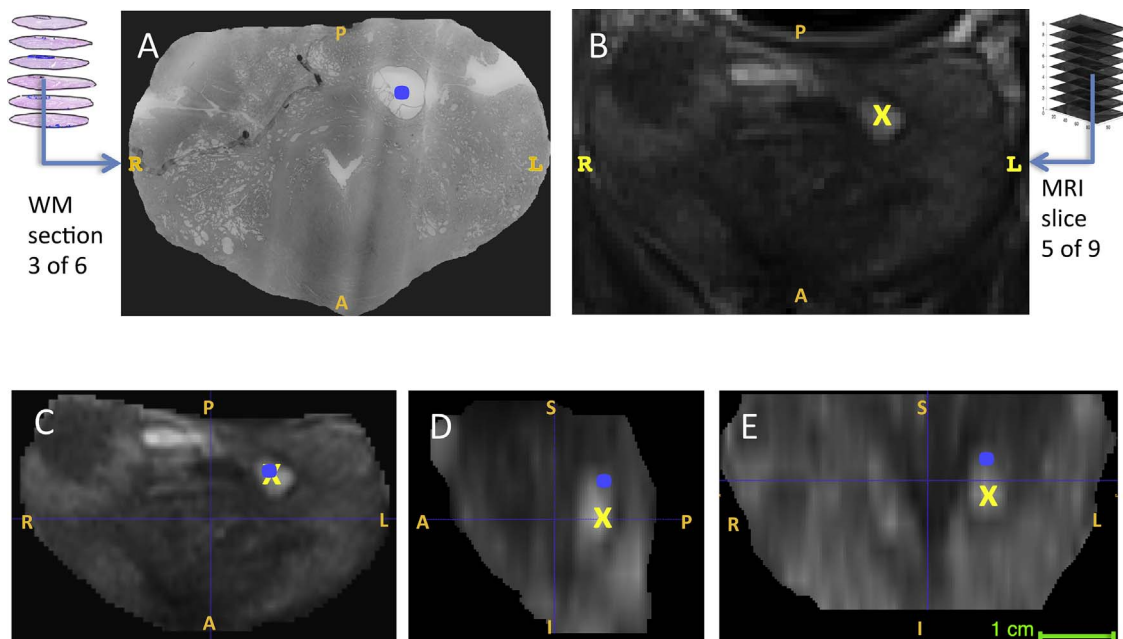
Example of landmark used to assess the registration accuracy. For this patient, WM section 3 of 6 (A) was used to define a landmark in pathology (blue dot), and MRI slice 5 of 9 (B) used to define the corresponding imaging landmark (yellow x). In the bottom row, the landmark positions are shown after registration overlaid on the MRI slice in transversal (C), sagittal (D) and coronal plane (E). Registration error for this landmark was 5 mm. (For interpretation of the references to color in this figure legend, the reader is referred to the web version of this article.)
